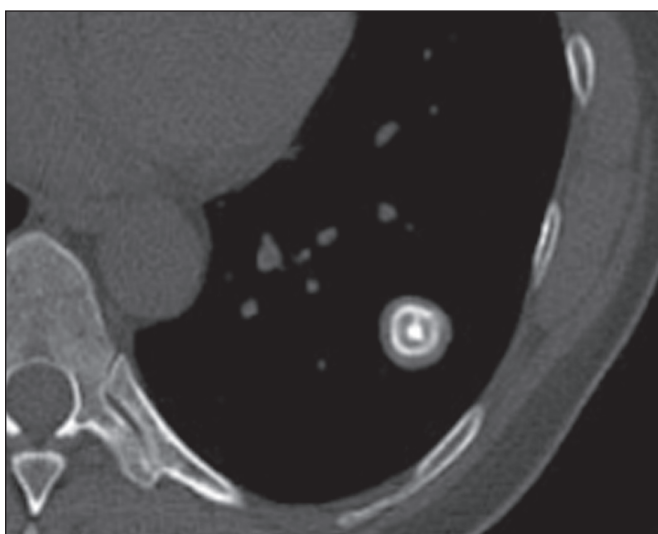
CT of a 37-year-old man with a histoplasmoma, showing a nodule, with smooth contours and concentric laminar calcifications, in the left lower lobe.
